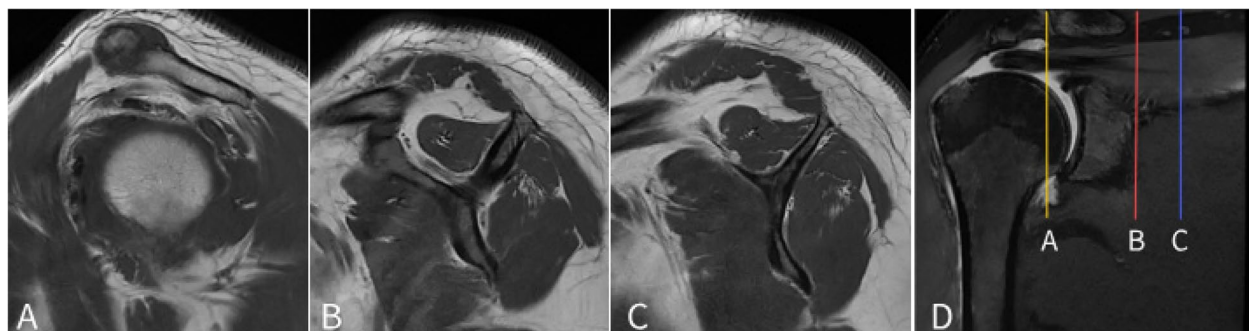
MR images of patients with stage 2 tendon retraction according to the Patte classification. A A sagittal section more lateral than the Y view and close to the tendon stump; (B) T1-weighted MR image of the Y view; (C) T1-weighted MR image of the r view; (D) T2-weighted coronal view of the shoulder MRI showing the anatomical localization of three sections in the scapula
